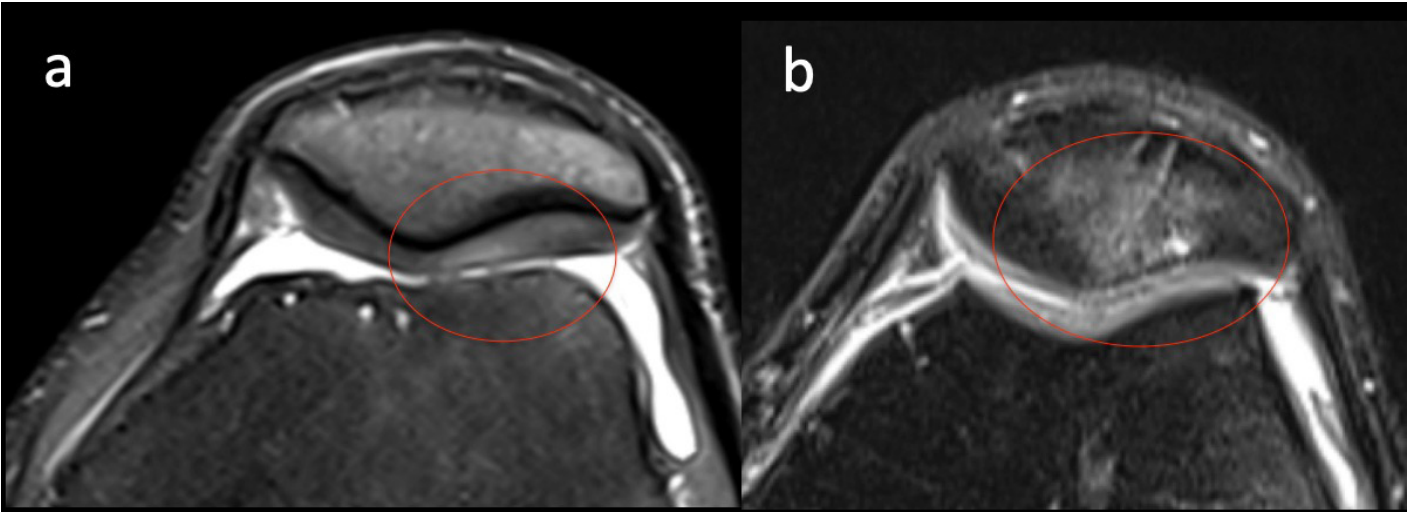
Proton density-weighted axial MRI findings of patellofemoral cartilage damage; (a) Increased lateral patellar cartilage signal intensity; (b) Lateral patellofemoral cartilage damage with subchondral bone marrow edema and degenerative subchondral cyst formation
